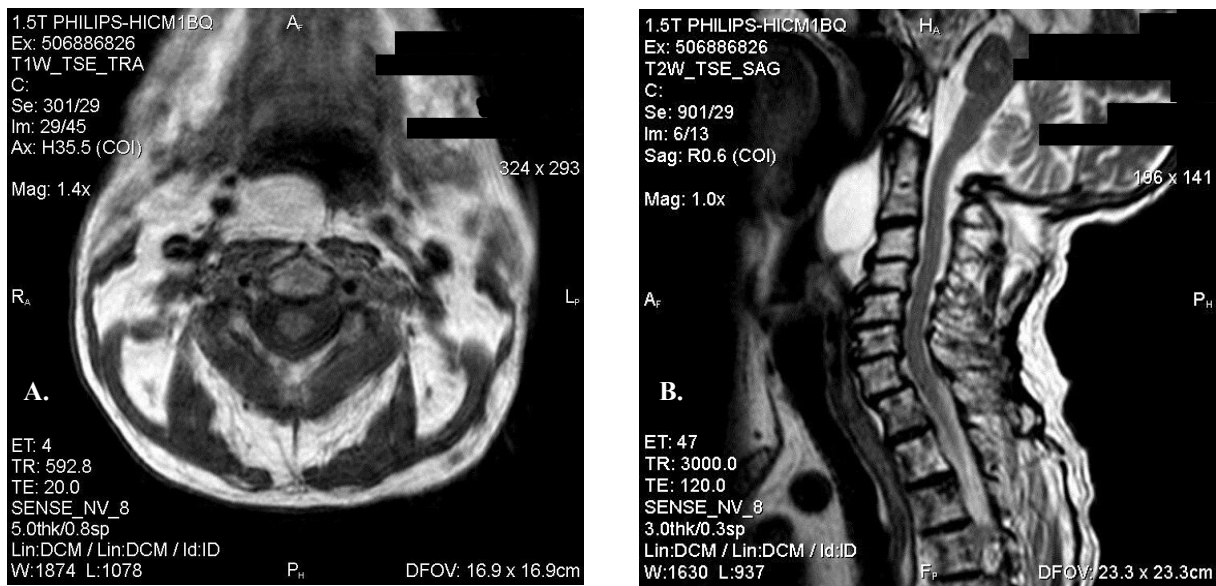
Preoperative magnetic resonance imaging of the reported case, A) axial T1-weighted image at the level of hypopharynx showing a lesion at the retropharyngeal space slightly on the midline right, B) sagittal T1-weighted image of the neck showing a high signal lesion at the retropharyngeal space extending from the level of the soft palate to the vallecula.
